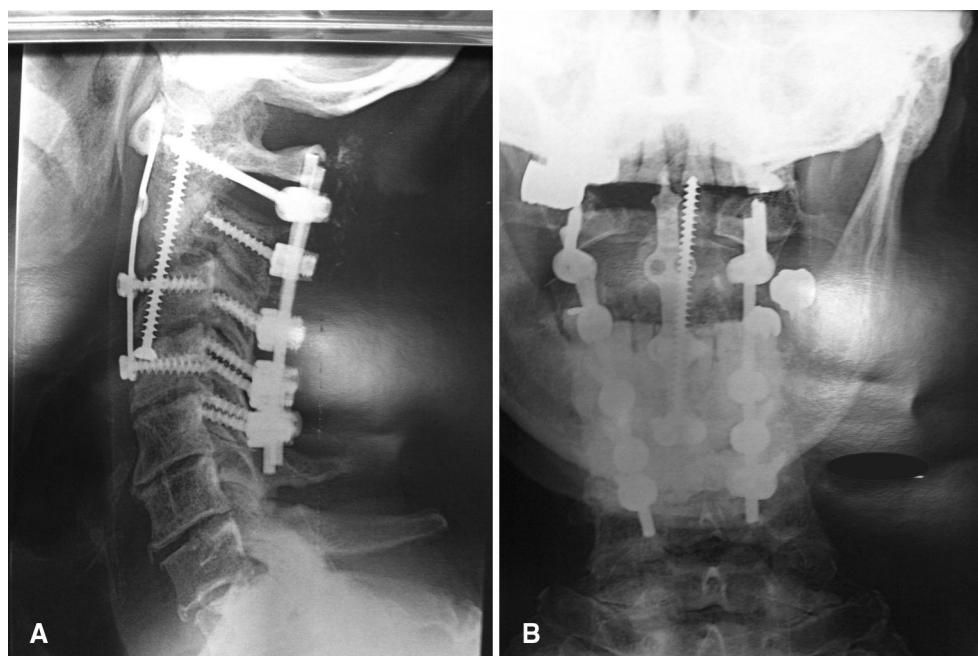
Lateral X-ray showing a stable construct at 1 year
